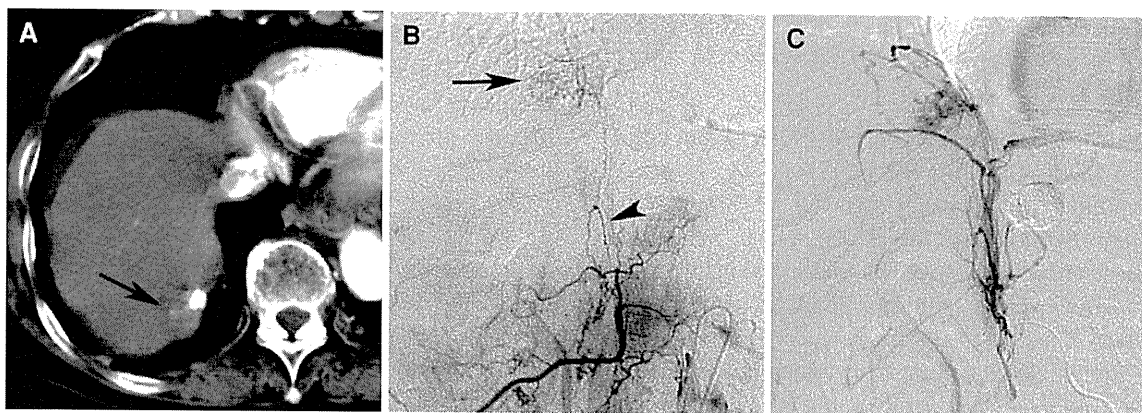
A 71-year-old woman with an HCC located in the bare area. A Arterial phase CT at the third recurrence 4 years 2 months after the initial treatment shows a tumor protruding to the bare area (*arrow*). B The tumor was initially supplied by the hepatic arterial branch and was supplied by the right IPA at the first and second recurrences (not
